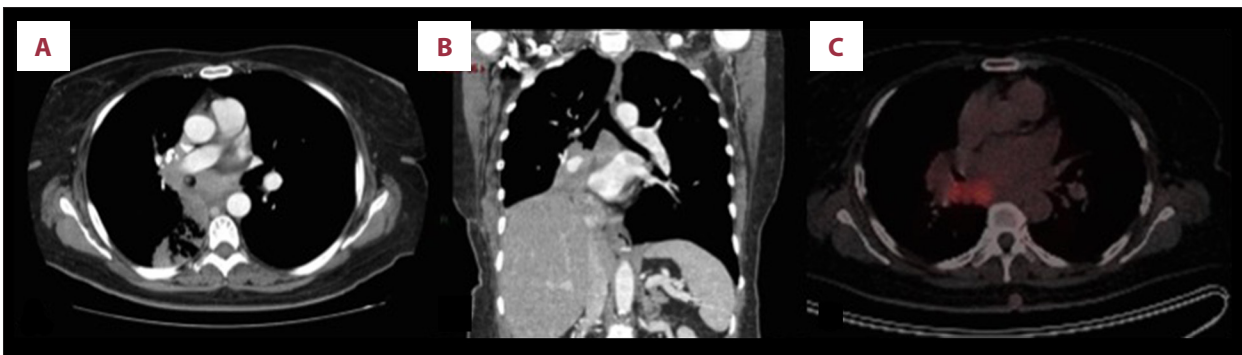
(A, B) In the axial image and the coronal reconstruction of the chest tomography with contrast, a mass with a soft tissue density is observed, which completely compromises the lumen of the intermediate bronchus and the right lower lobe, and partially compromises the lumen of the middle lobar bronchus with associated post-obstructive atelectasis. (C) Positron emission tomography shows the hypermetabolic mass of poorly defined margins, located in the upper segment of the right lower lobe, approximately 59×59×81 mm (APxTxL) (max SUV 18.6).
